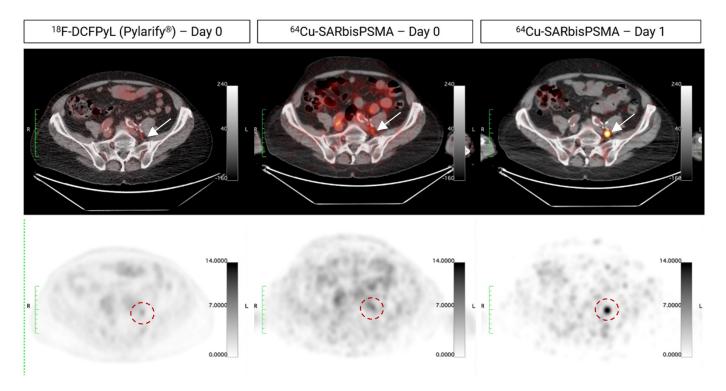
Identification of lesion in the pelvic region using ⁶⁴Cu-SAR-bisPSMA on next-day imaging (right), negative on same-day imaging (⁶⁴Cu-SAR-bisPSMA; center) and equivocal on screening SOC imaging (¹⁸F-DCFPyL, Pylarify®; left). Maximum standardised uptake values (SUVmax) of the lesion across scans (arrows and red circles) was 2.3, 4.3 and 17.5 (¹⁸F-DCFPyL, Pylarify®, Day 0 and Day 1 ⁶⁴Cu-SAR-bisPSMA, respectively). Top images: PET/CT fusion. Bottom images: PET.
